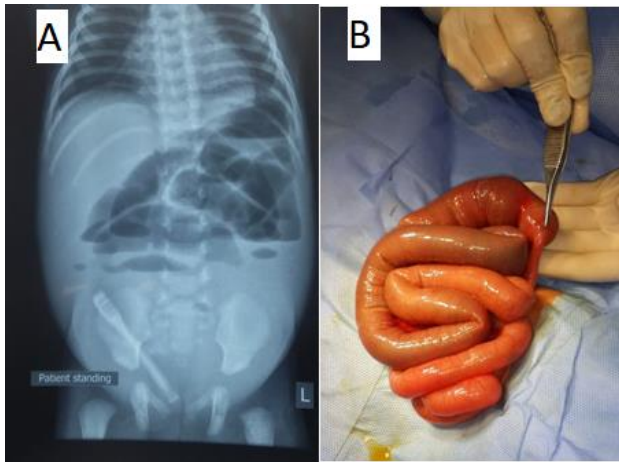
A) X-ray showing intestinal obstruction, B) Intraluminal web causing obstruction.
